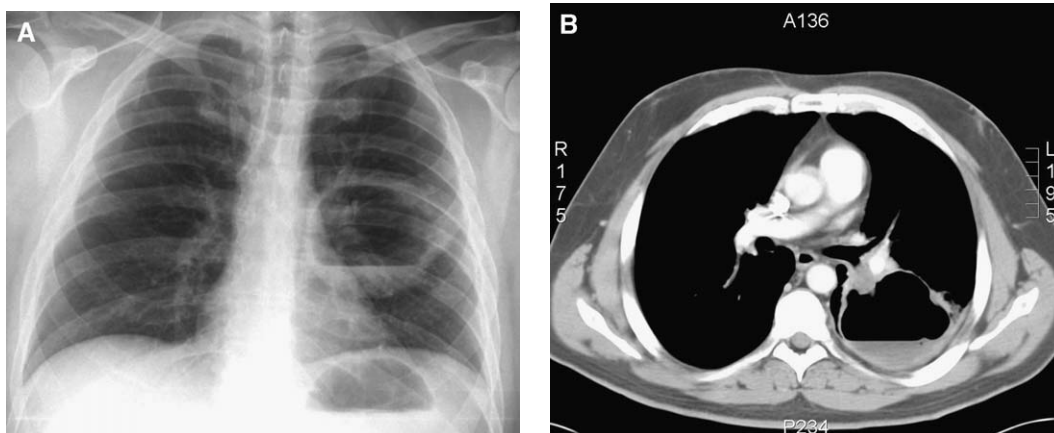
Lung abscess. (A) PA chest. (B) CT scan.
